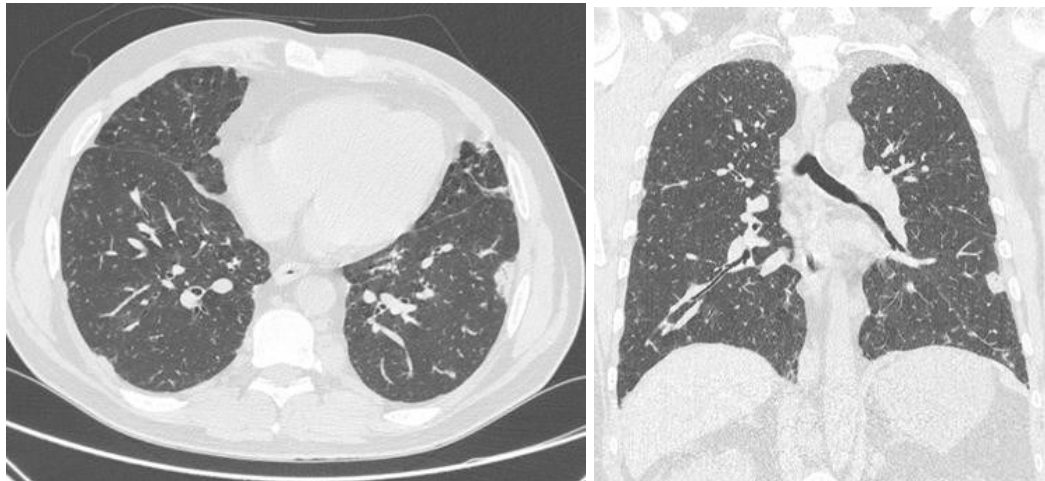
Typical HRCT pattern of one of our GLILD patients.
